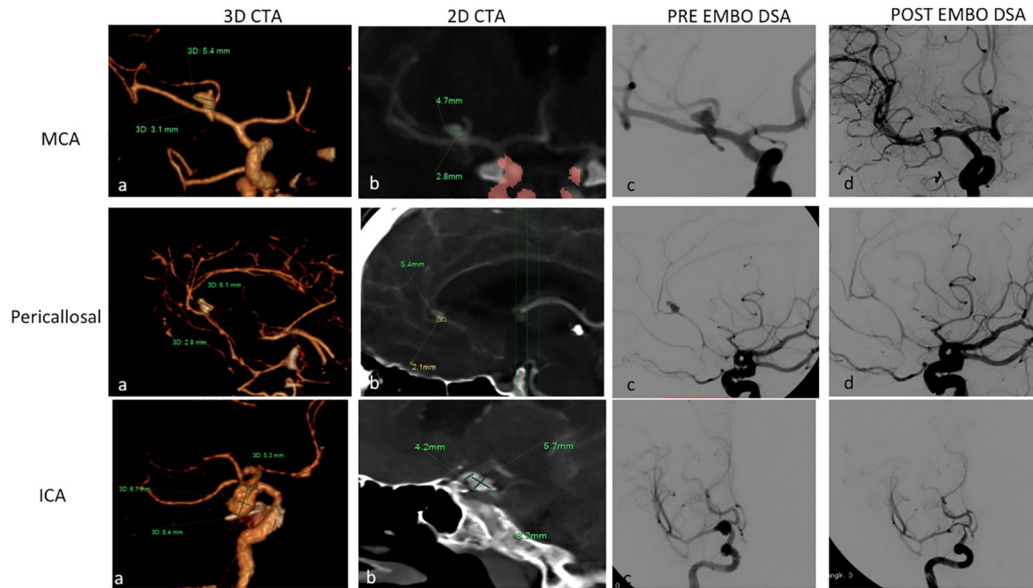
Three different patients. 3D CTA (a), 2D CTA (b) reconstructions and DSA pre (c), and post (d) embolisation of an MCA bifurcation (1st row), pericallosal (2nd row) and ICA (3rd row) aneurysms.
